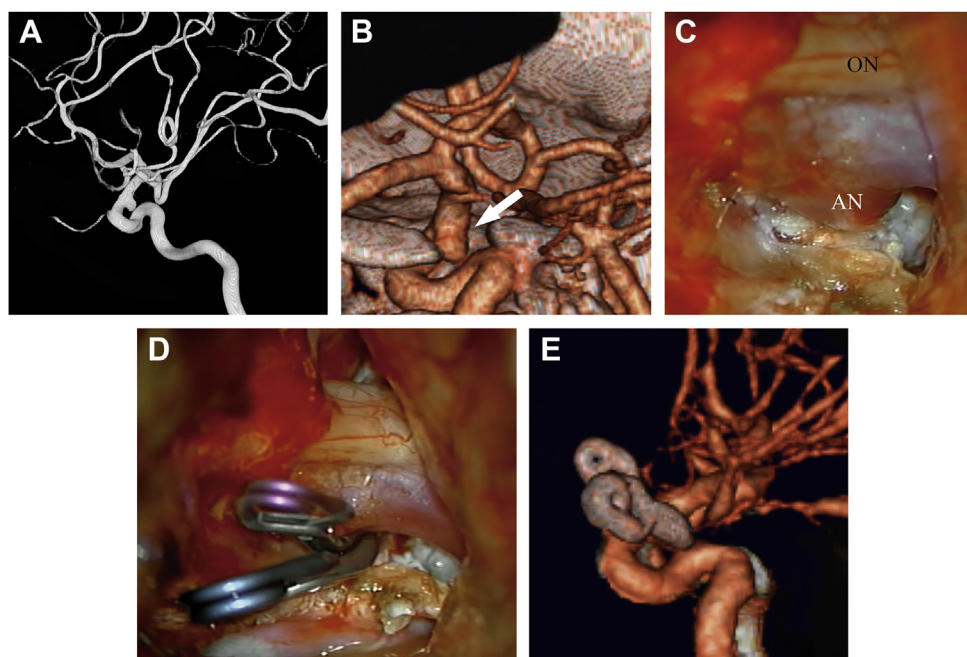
(A) Three-dimensional digital subtraction angiography demonstrating 8-mm left side clinoidal–ophthalmic segment aneurysm. (B) Three-dimensional computed tomography angiography demonstrating 8-mm left side clinoidal–ophthalmic segment aneurysm and relationship with left anterior clinoid process. White arrow showing paraophthalmic aneurysm. (C) Intraoperative picture after performing
